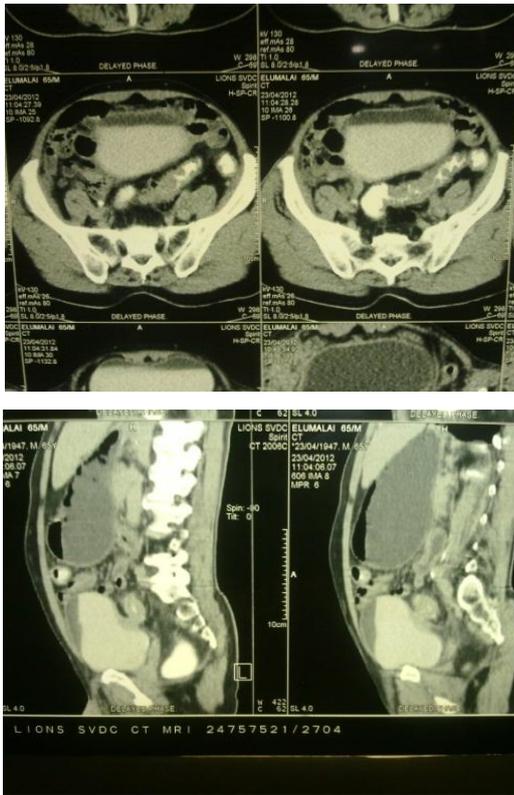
Contrast CT showing Segmental thickening of the Sigmoid tethering to the bladder wall
